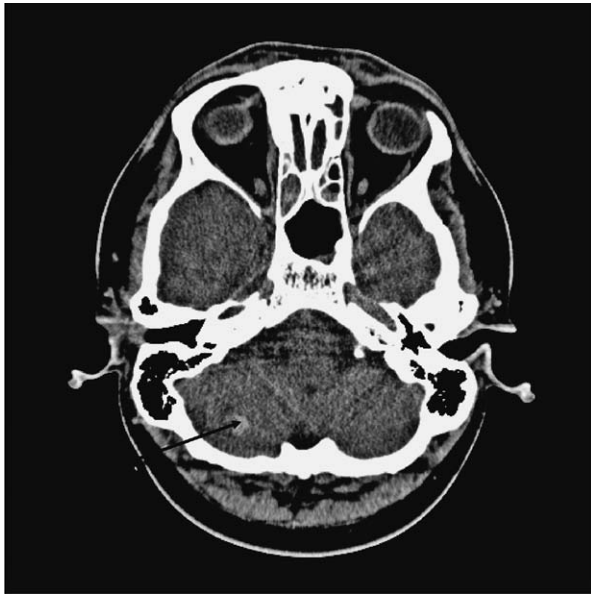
Computed tomography scan demonstrates traumatic cerebellar hematoma measuring 11 mm.
